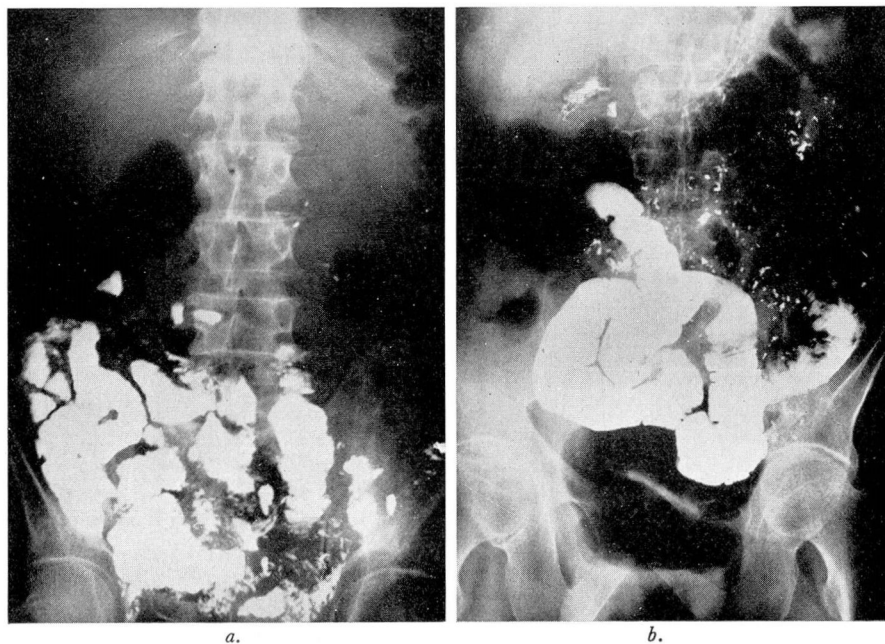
(a) Small intestinal x-ray in patient with sprue showing dilatation, moulage, and segmentation. (b) Small intestinal x-ray in patient with sprue showing dilatation and moulage of the intestinal wall.
